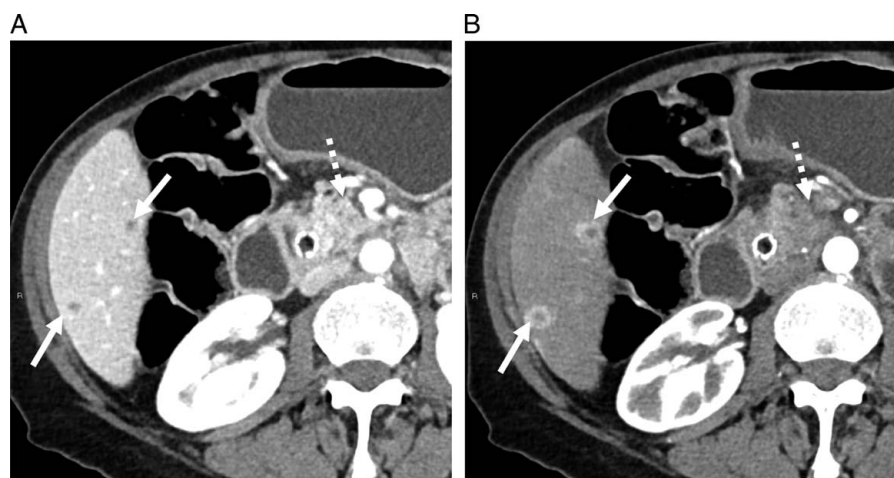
A 61-year-old woman with metastatic pancreatic adenosquamous carcinoma. (A) An axial intravenous (i.v.) contrast-enhanced computed tomography (CT) image in the portal venous phase showed small hypoenhancing liver lesions (arrows) and an ill-defined hypoenhancing pancreatic head mass (dotted arrow). These small lesions would be difficult to characterize based solely on venous phase imaging appearance. (B) An axial i.v. contrast-enhanced CT image in the arterial phase showed avid enhancement along the periphery of the liver lesions (arrows). The targetoid appearance significantly improved the diagnostic confidence of liver metastases. An ill-defined pancreatic head mass (arrowhead), compatible with pancreatic cancer, is visible.
